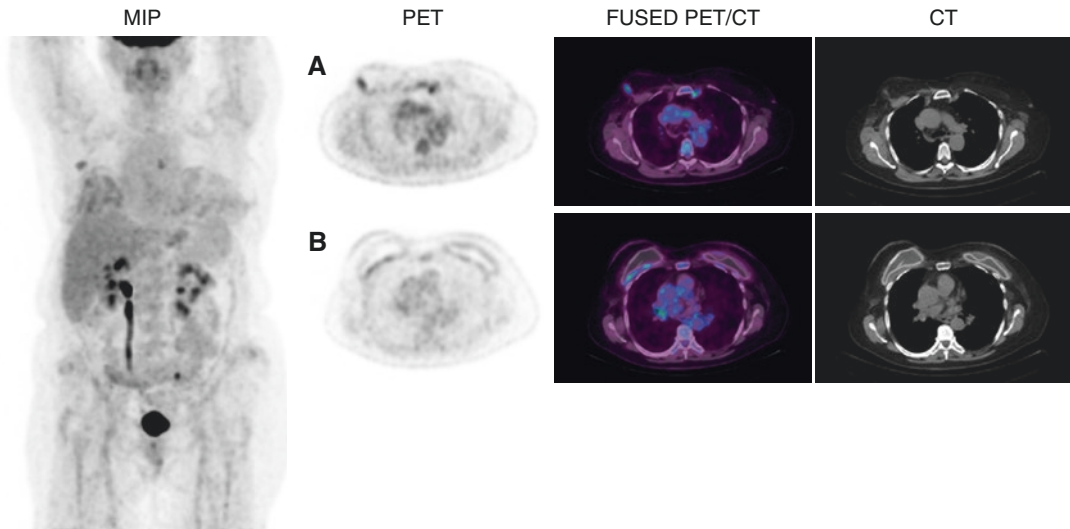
Scan findings: Breast MR shows a lesion of 52 × 30 mm in the right upper outer quadrant (red head arrow). FDG PET/CT showed no significant uptake in the known lesion
